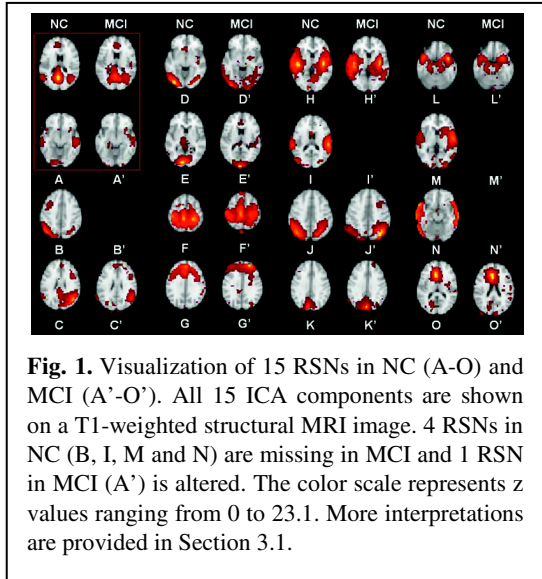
Visualization of 15 RSNs in NC (A-O) and MCI (A'-O'). All 15 ICA components are shown on a T1-weighted structural MRI image. 4 RSNs in NC (B, I, M and N) are missing in MCI and 1 RSN in MCI (A') is altered. The color scale represents z values ranging from 0 to 23.1. More interpretations are provided in Section 3.1.
